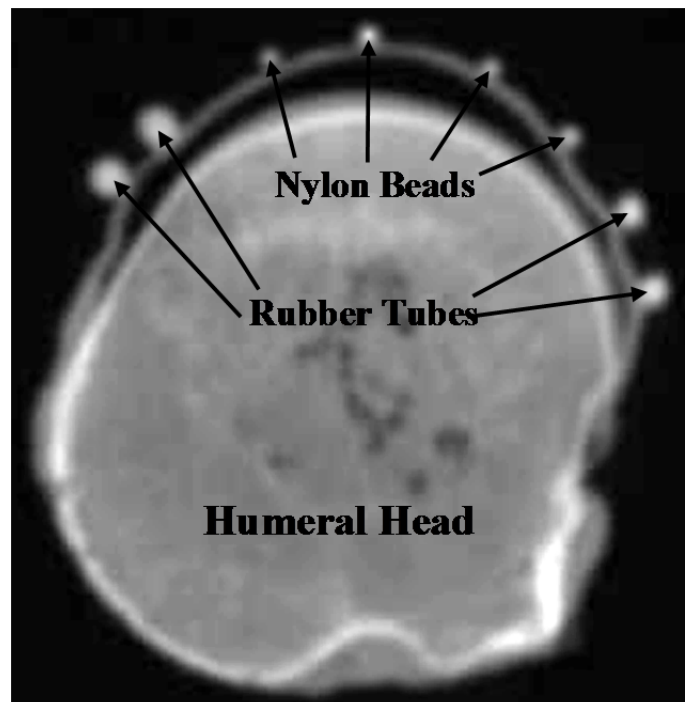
CT image of the humeral head and IGHL complex. Rubber tubes and nylon beads mark the boundaries of the AB-IGHL, PB-IGHL, and axillary pouch.
